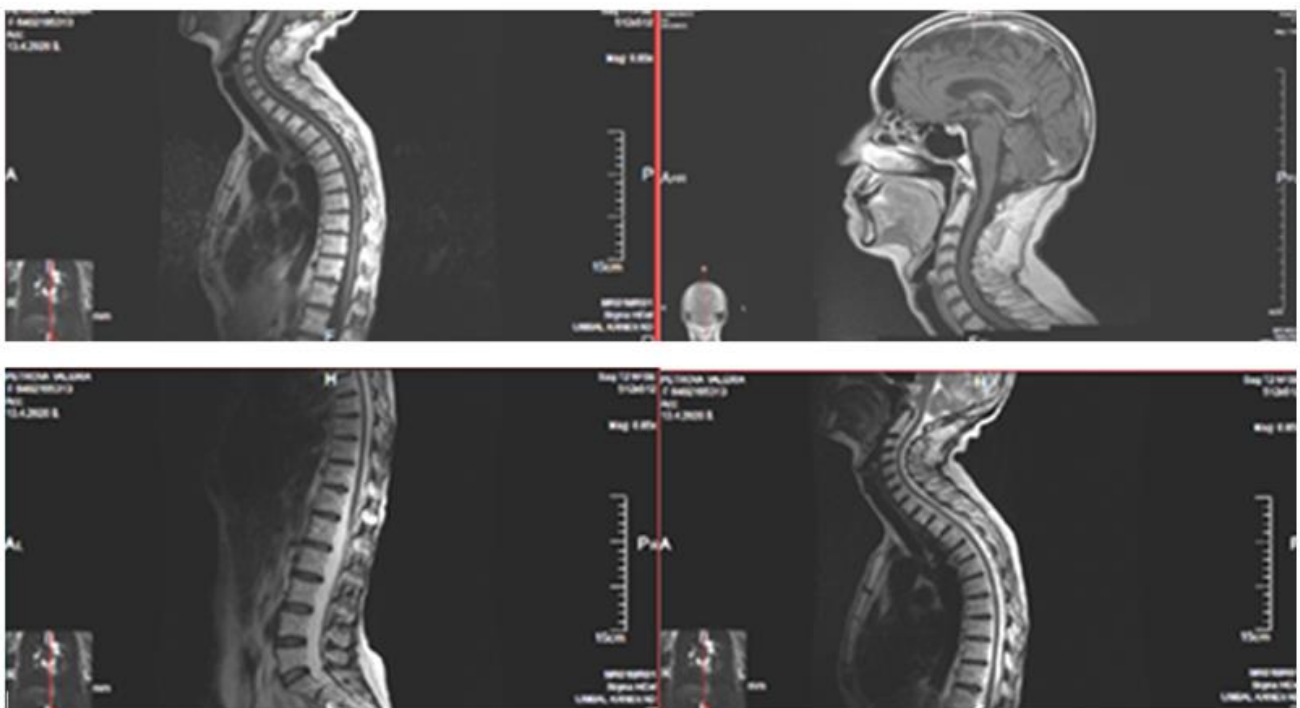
SAG T2 and SAG T1+C postcontrast MR images of the spinal column without leptomeningeal metastases in the spinal cord
